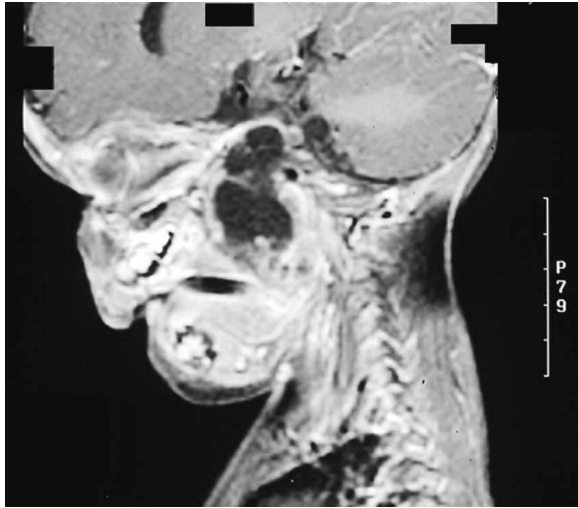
CT of case 3 showing a teratoma of the skull base with an intracranial extension.
